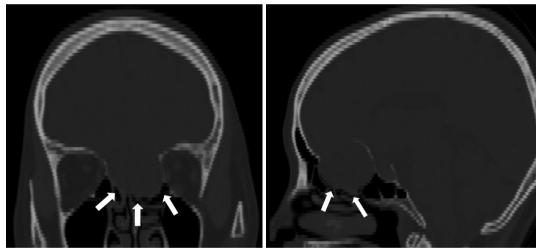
Coronal and sagittal reconstruction images of computed tomography scan reveal bony thinning or erosion on anterior skull base (white arrows).
